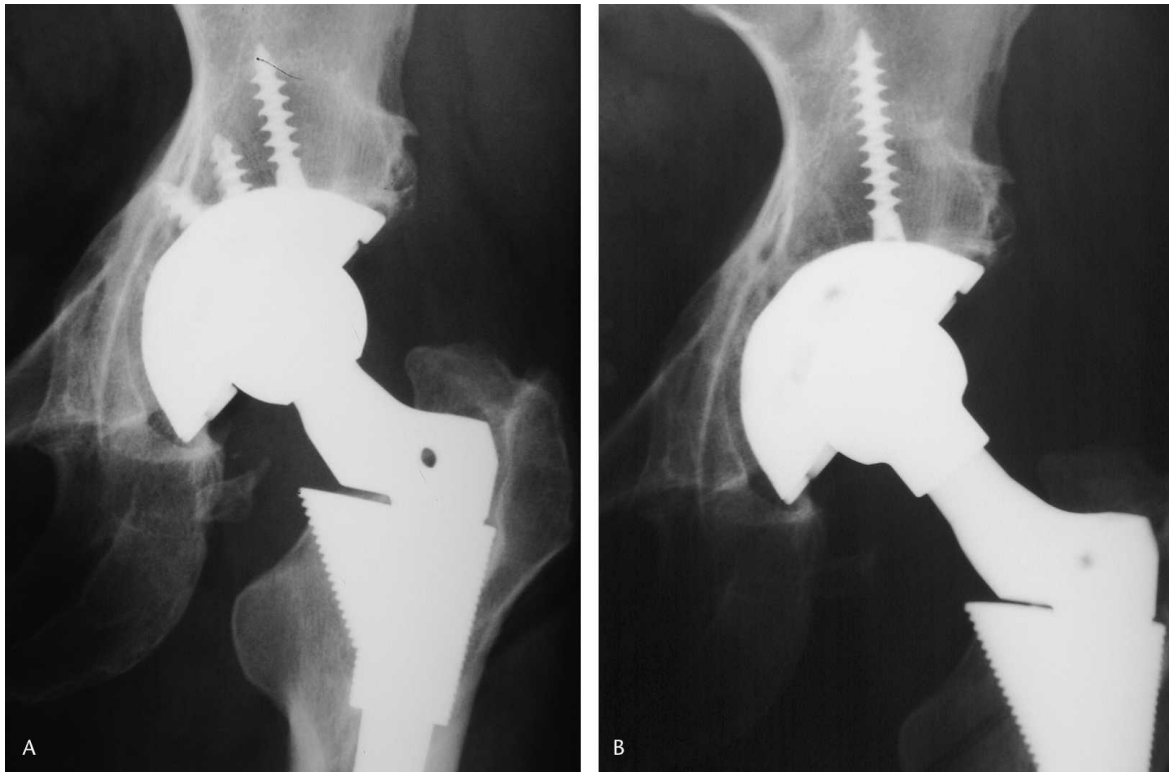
(A) An AP radiograph of the left hip of shows a 51-year-old woman who presented with osteolysis secondary to PE wear 8.5 years after primary cementless THA. The patient had an S-ROM[®] femoral component, a 28 mm ceramic head with standard neck, and a Universal RingLoc[®] acetabular component (Biomet, Warsaw, IN) for treatment of rheumatoid arthritis. She had a history of acetabular fracture. The patient had a dislocation 2 weeks postoperatively and was treated successfully with closed reduction. (B) A radiograph taken immediately after revision surgery shows a change of the acetabular liner, and a change to a 28-mm Co-Cr femoral head with a 12 mm skirted neck. The patient experienced three dislocations beginning 2 years after the liner exchange surgery. The patient subsequently had a full revision of the acetabular component at another institution.
